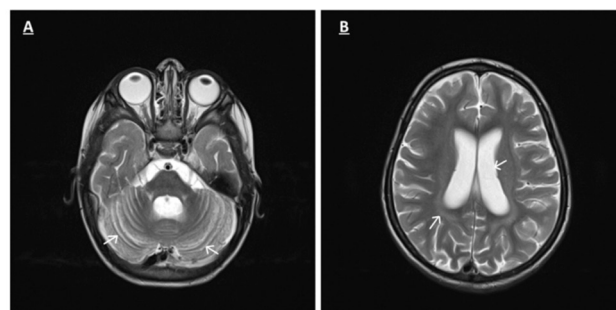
Axial T2 weighted MRI images A and B) of patient B show enlarging of cerebellum folia , cortical sulci and ventricles with slight hyperintensity of cerebral white matter related to early cerebellar atrophy.
